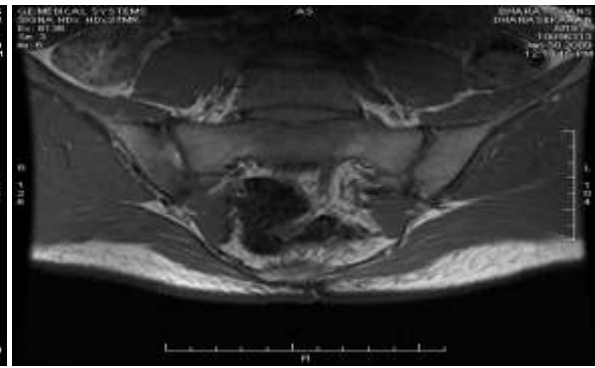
Same case with MRI showing R. Sacroiliitis
